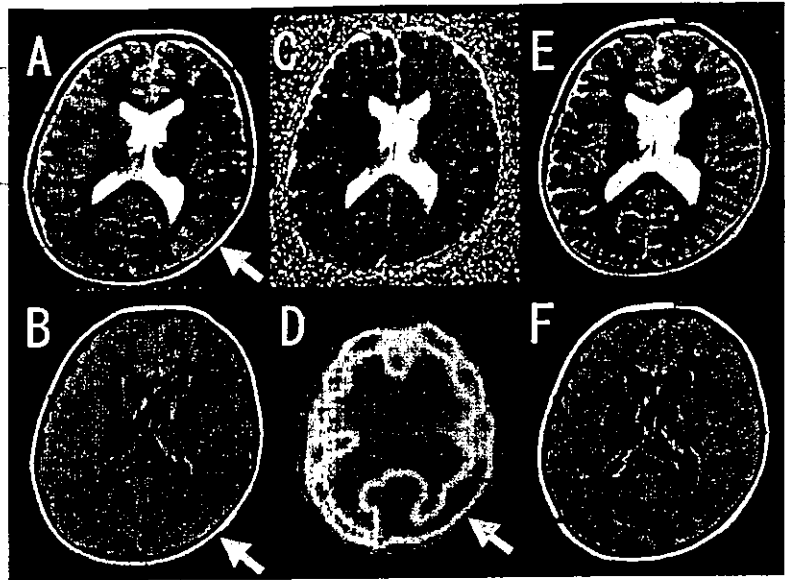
MRI revealed signal hyperintensity by T₂-weighted (A) and FLAIR (B) images in the left temporo-occipital region. DWI of MRI did not demonstrate abnormal intensity area (C). Simultaneously examined SPECT showed hyperperfusion in the left temporo-occipital cortex (D). The 4-month follow-up MRI exhibited no signal abnormality or cortical atrophy by T₂-weighted (E) and FLAIR (F) images. Both MRIs demonstrated mild dilatation of the posterior horn of the left lateral ventricle. (A) T₂-weighted image: Fast spin echo, TR/TE 4000/107 msec, (B) FLAIR image: TR/TE/TI 9002/150/2200 msec, (C) DWI: apparent diffusion constant (ADC) image, TR/TE 5000, 102.5 msec, b value=600, 800, 1000, (E) T₂-weighted image: Fast spin echo, TR/TE 4000/102 msec, (F) FLAIR image: TR/TE/TI 10002/172/2200 msec. TR: repetition time, TE: echo time, TI: inversion time.
